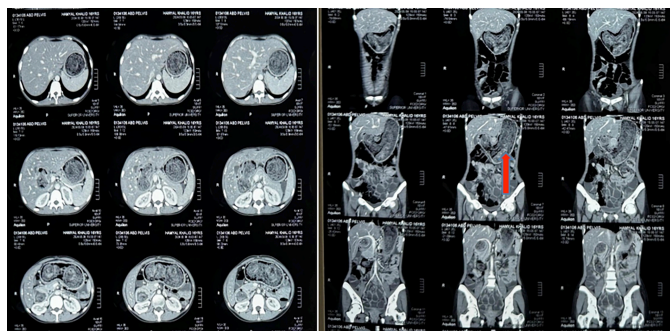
Axial and coronal views of CT scan of the abdomen showing a mass completely filling the stomach and extending into duodenum and jejunum (red arrows).
